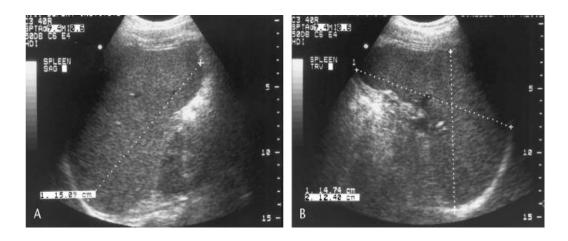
Sonographs show (A) Splenomegaly (15.09 cm) in length (B) enlarged spleen measured (14.74X12.42 cm) (www.Ultrasound cases.info)
